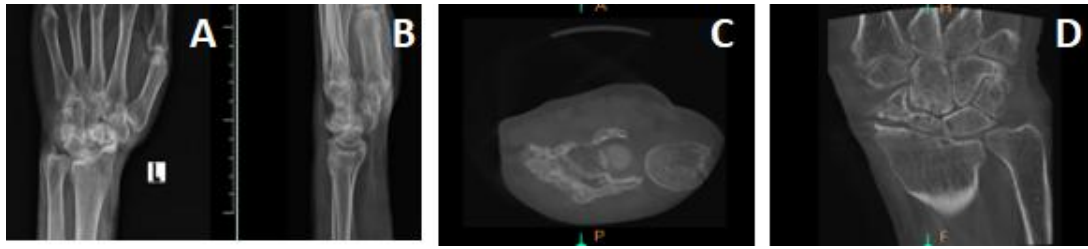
Fracture instability. General radiography (A,B) shows limited details, whereas CBCT images (C,D) reveal fracture instability more accurately.
